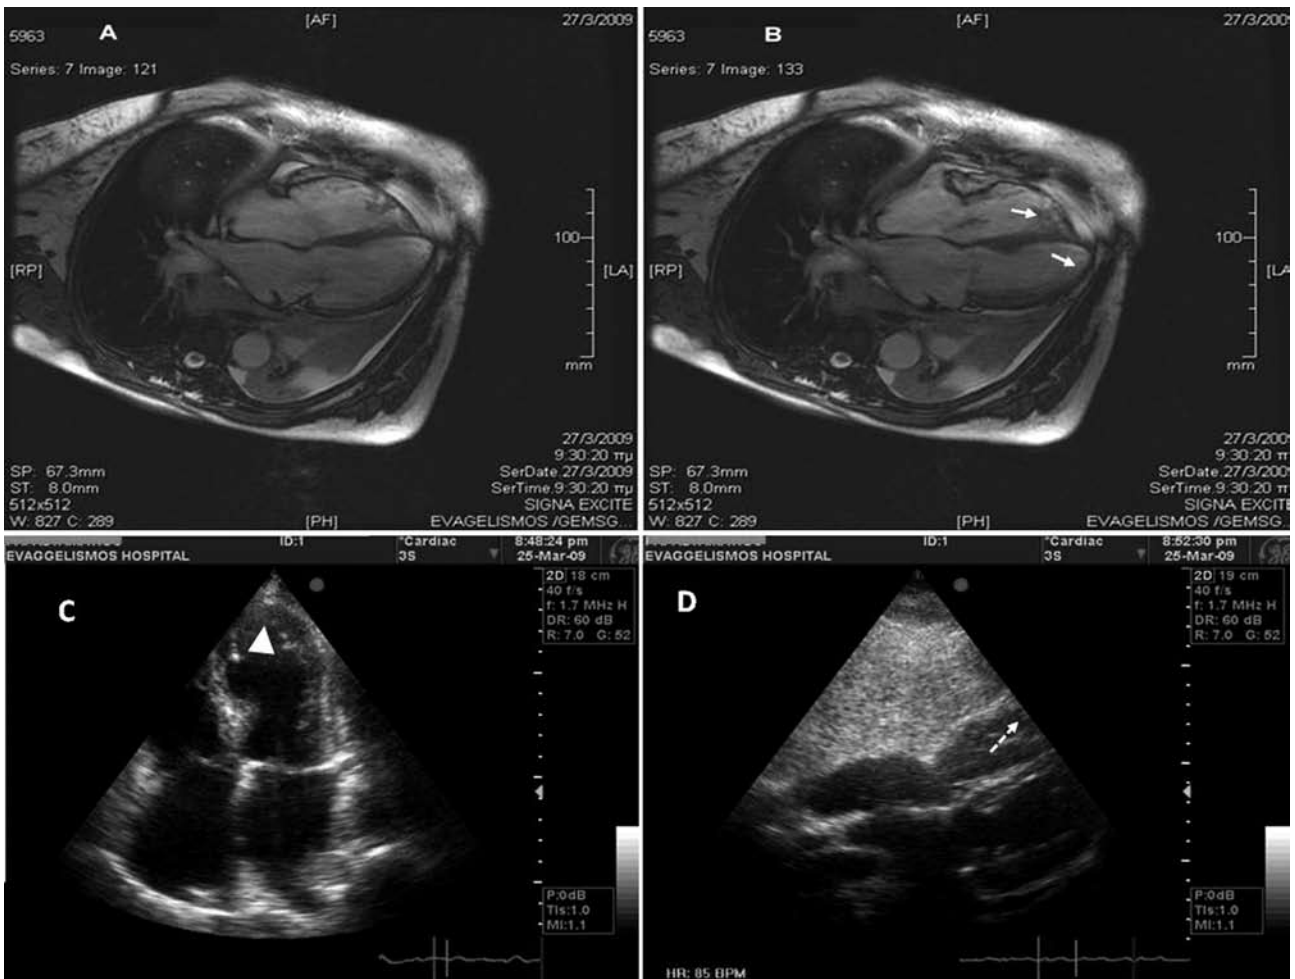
A, B: MRI findings supported the biventricular apical akinesia (arrows) during diastole (A) and systole (B). C, D: Transthoracic echocardiogram showed left ventricular apical akinesia in the four-chamber view (C) and right ventricular apical akinesia in the subcostal view (D).
